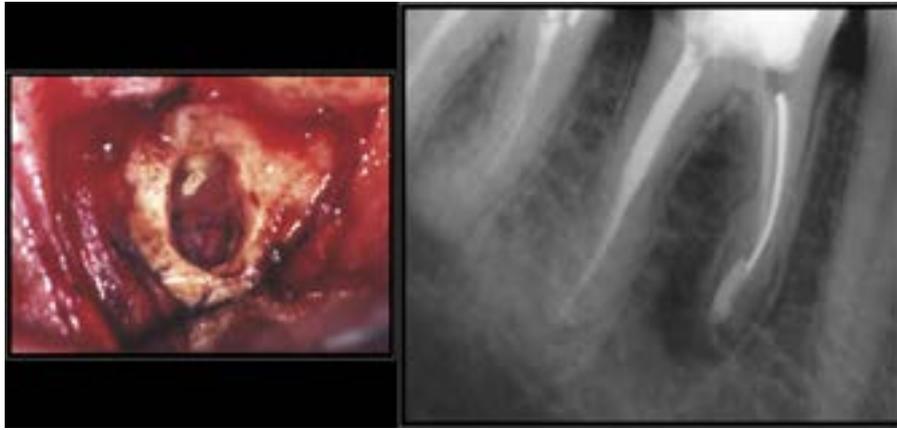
Post-operative X-ray of tooth 4.6.
